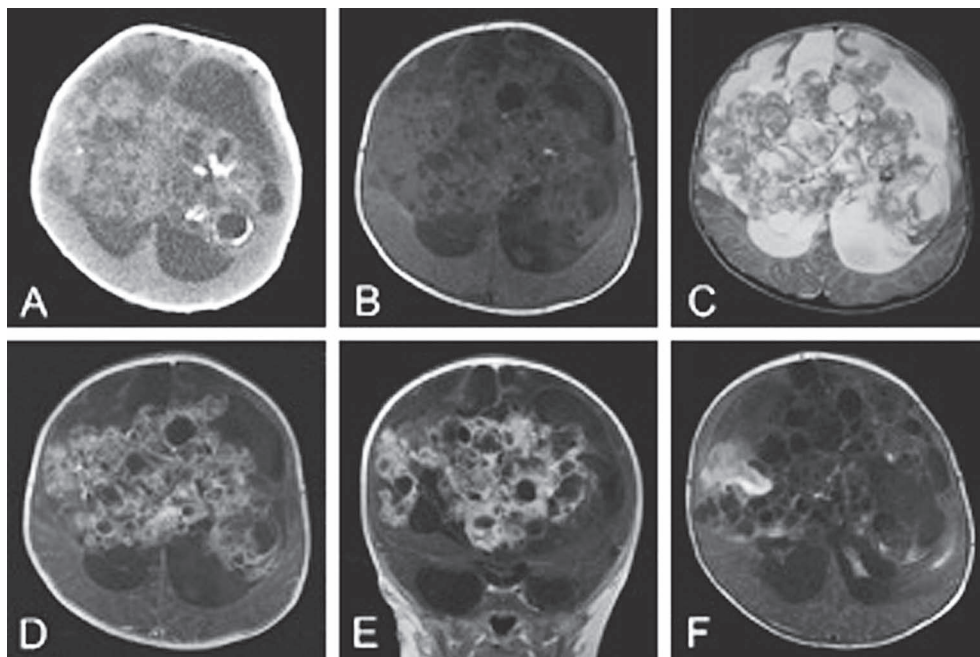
CT scan and MR images at initial presentation and after chemotherapy initiation.
